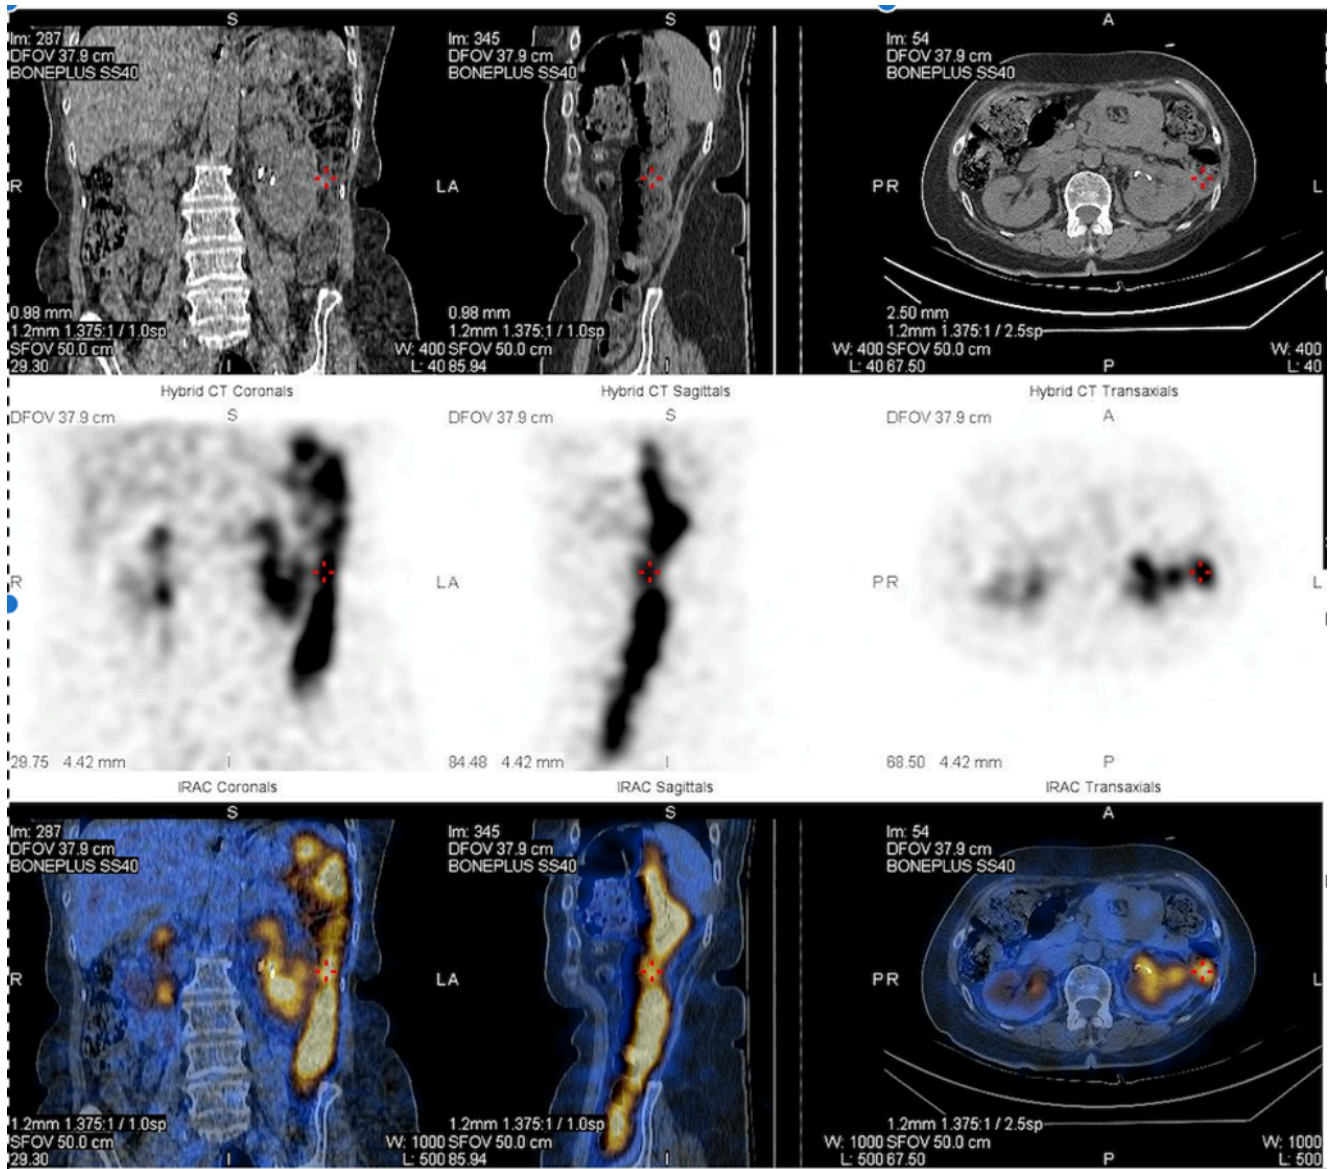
SPECT-CT abdomen reveals tracer accumulation along the left abdomen corresponds to uptake within the descending colon.
